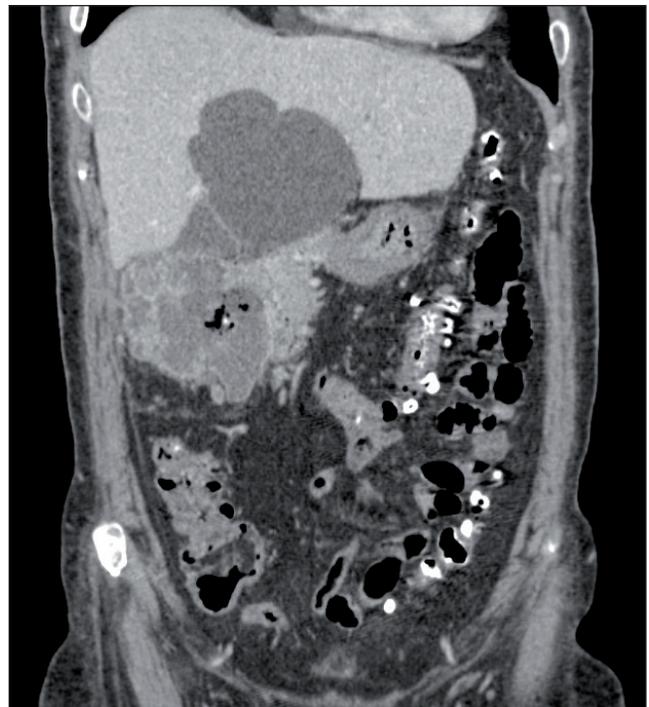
Abdominopelvic CT image with intravenous contrast. Coronal cut. Presence of a renal mass depending of the right kidney lower pole. Hypodense areas can be observed on the inside, suggesting a necrotic component and peripheral uptake of contrast. The inner border is bad defined and its limits are vanishing, forming a tumoral magma which is intimately adherent to the duodenal bulb and second portion of duodenum and the head of the pancreas. It also shows presence of air bubbles in the front upper part of the mass, near the area adjacent to the duodenum, suggesting contained duodenal perforation. Dilatation of choledochus and intrahepatic bile duct (1 cm) conditioned by the compressive effect of the foresaid mass.
